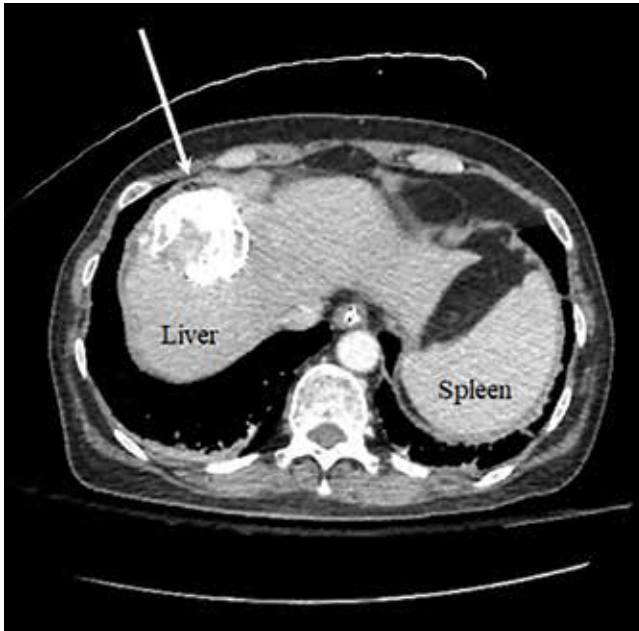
Computed tomography of the abdomen demonstrating a 4.7-cm lesion in the dome of the right hepatic lobe (arrow) containing hyperdense material with hypodense areas, likely related to earlier transarterial chemoembolization treatment.
